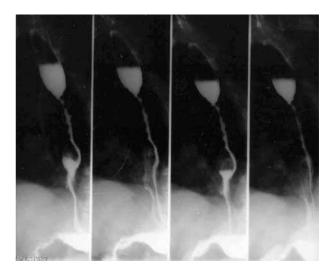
Contrast radiography with barium showed an incomplete stenosis of the mid-oesophagus with a length of 7 cm.
